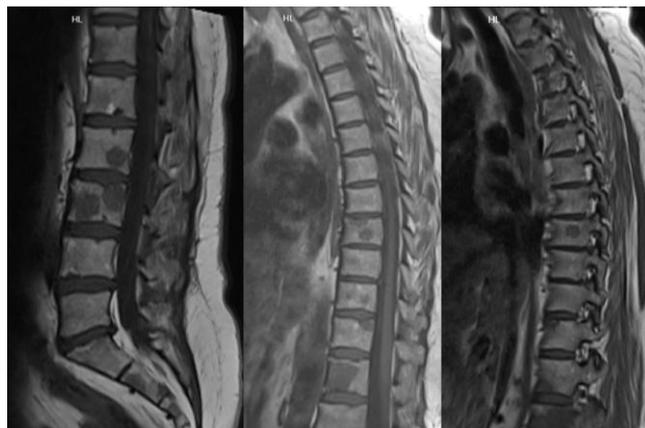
Low-density multiple involvement areas on T1-weighted sagittal MR imaging of the thoracolumbar spine
